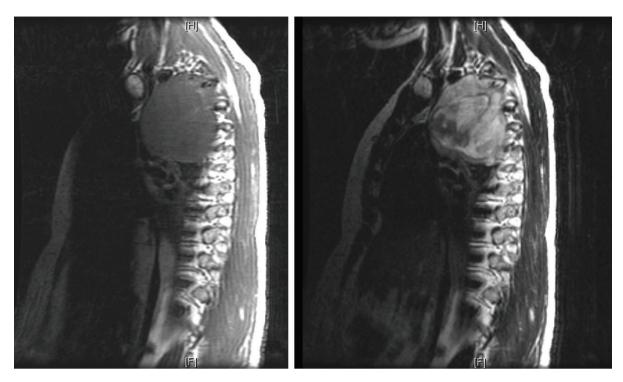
MRI T1 (left) and T2 (right) sagittal views of the thoracic cage.
